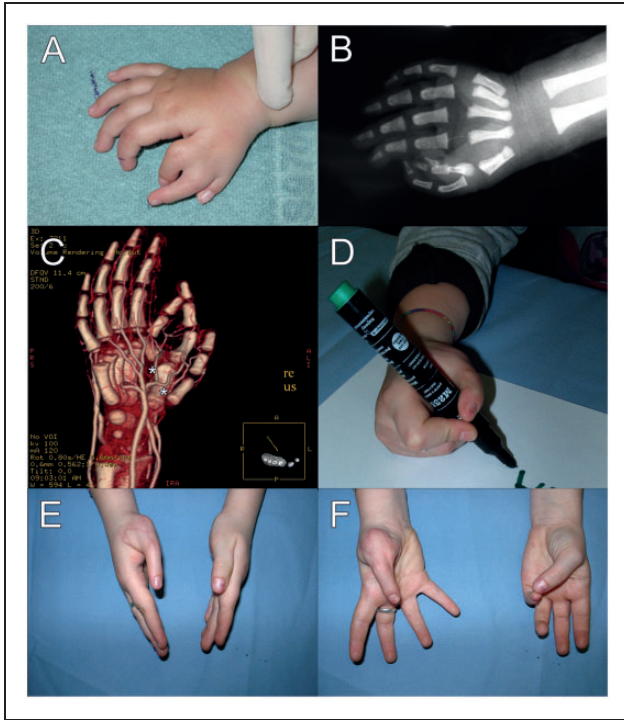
(a) An 11-month-old girl with a triplicated thumb, Wassel Type VII, the radial thumb being hypoplastic, Blauth type IIIB. (b) Plain X-rays were not useful for surgical planning because of marked overlay of bony structure, which did not provide additional information beyond the clinical examination. (c) MDCT angiography (Online Video Supplement 1) showed that the radial artery (asterisks) supplied exclusively the triplicated thumb and the radial side of the second digit. No connection between radial and ulnar arteries making up the superficial or deep palmar arch was detected. The radial artery and its branches exclusively supplied the thumb triplication. The knowledge of arterial anatomy permitted precise vessel preparation during surgery ((c), asterisks). The hypoplastic radial thumb and the ulnar thumb were resected, followed by pollicizing the middle triphalangeal thumb. (d)–(f) The result after secondary reposition and stabilization of the metacarpal head, indicating excellent thumb position and function 5 years later.
